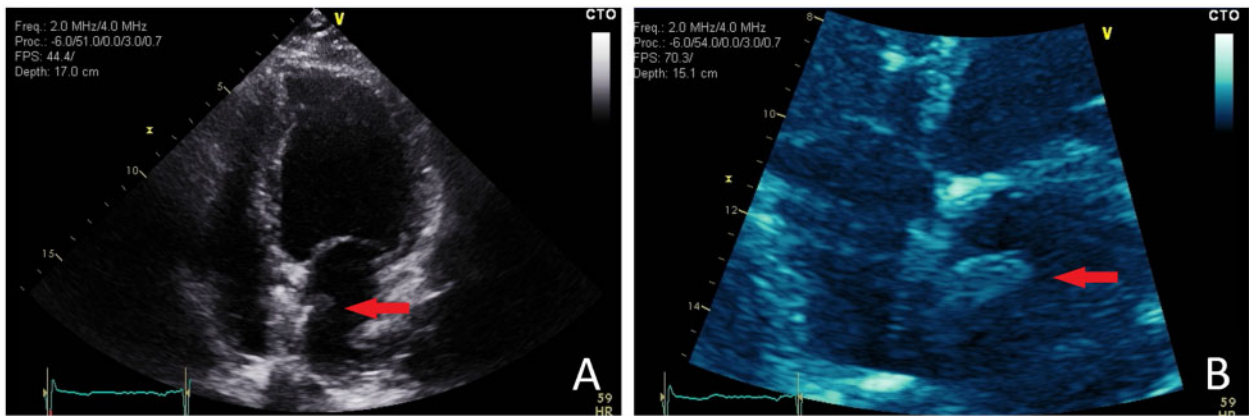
(A) Post-anticoagulation apical four-chamber view showing reduced thrombus (red arrow) size 6 days following initiation of anticoagulation. (B) Post-anticoagulation zoomed apical four-chamber view showing residual left atrial thrombus adjacent to patent foramen ovale-closure device (red arrow).
